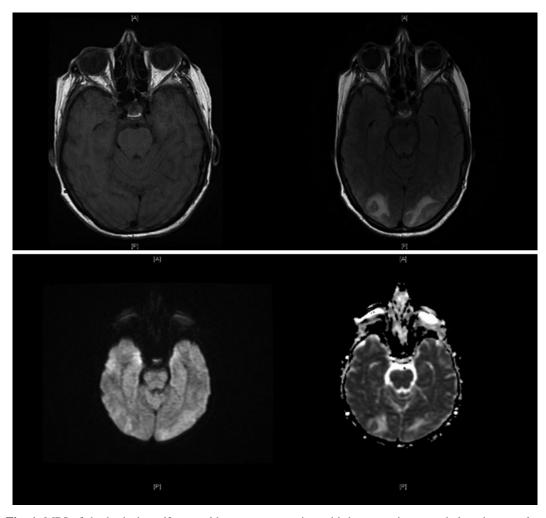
MRI of the brain in a 62-year-old woman presenting with hypertensive encephalopathy reveals predominance of vasogenic edema in the subcortical posterior white matter. Unenhanced T1-weighted image (*upper left*) showing isointense lesion; T2-weighted FLAIR image (*upper right*) showing increased signal in posterior *white* matter; Diffusion-weighted image and ADC map (*lower left and right*) showing no evidence of restricted diffusion.
